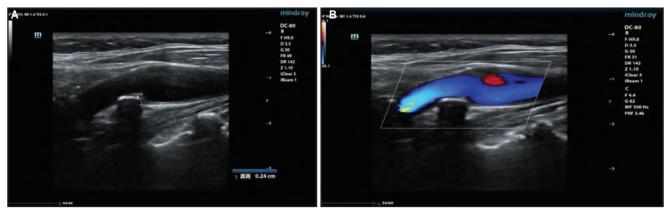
Conventional ultrasound of carotid mixed plaque.
